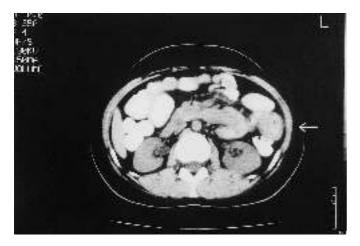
Abdominal computed tomography scan with enhancement showed a mass occupying the left side of the upper intra abdominal area, possibly corresponding to a jejunal polyp with signs of intestinal intussusception
